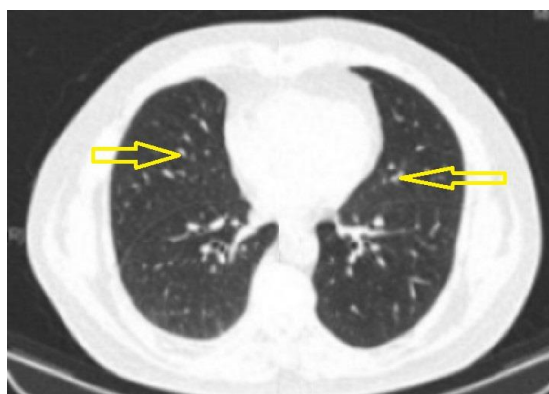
GGO on the CT scan image of lungs of COVID-19 negative patient
